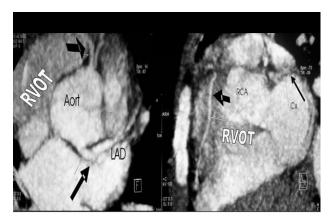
Axial multidetector computed tomography images display the findings of an abnormal coronary artery course and distribution in a patient with tetralogy of Fallot. RCA indicates right coronary artery; LAD, left anterior descending coronary artery; Cx, circumflex coronary artery; RVOT, right ventricular outflow tract.
